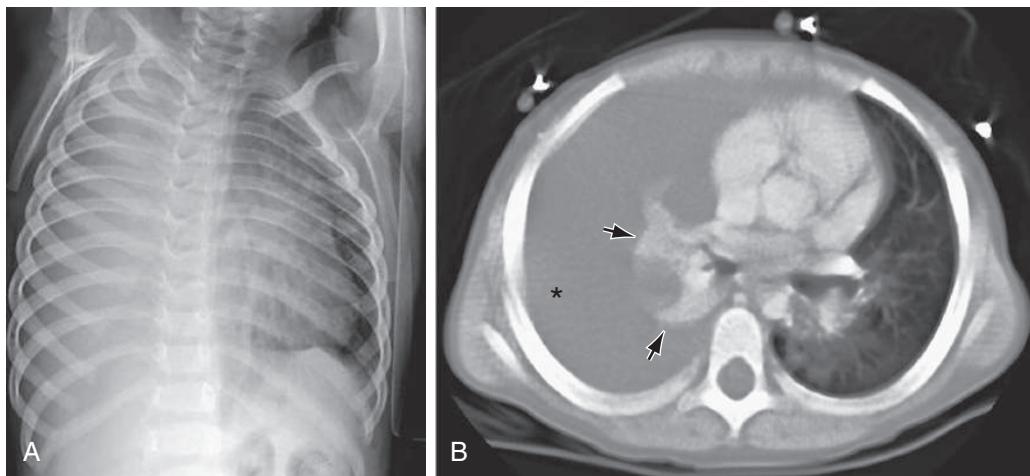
Spontaneous chylothorax in a 4 yr old with a duplication of chromosome 6. A, Chest radiograph shows opacification of the right thorax. B, CT scan shows the chylous pleural effusion (asterisk) compressing the atelectatic lung (arrows).
